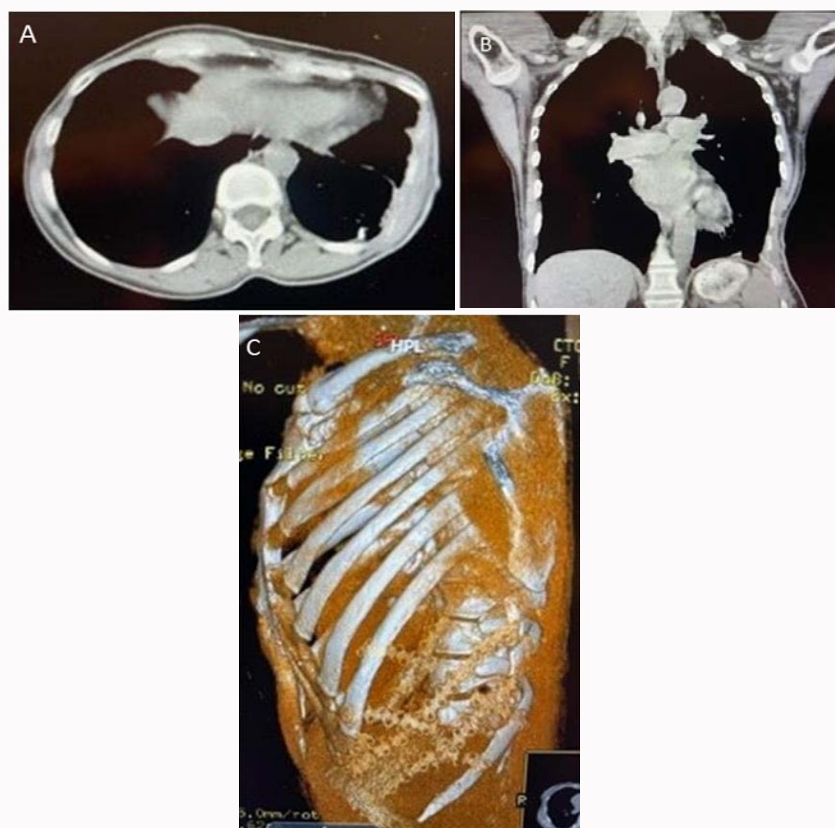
CT scans at 12 months follow-up.
